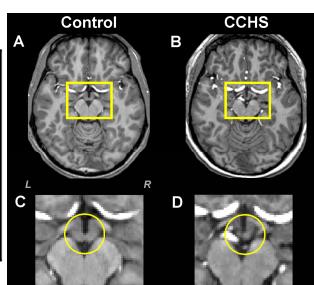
High-resolution T1-weighted images show mammillary bodies in a control (A; L = Left, R = Right) and CCHS (B) subject (yellow rectangles). Images (C) and (D) show magnified areas within the rectangles of the control (A) and CCHS (B). The right mammillary body in CCHS is smaller, and the left body is much smaller, compared to the control (C vs D, yellow circles).
